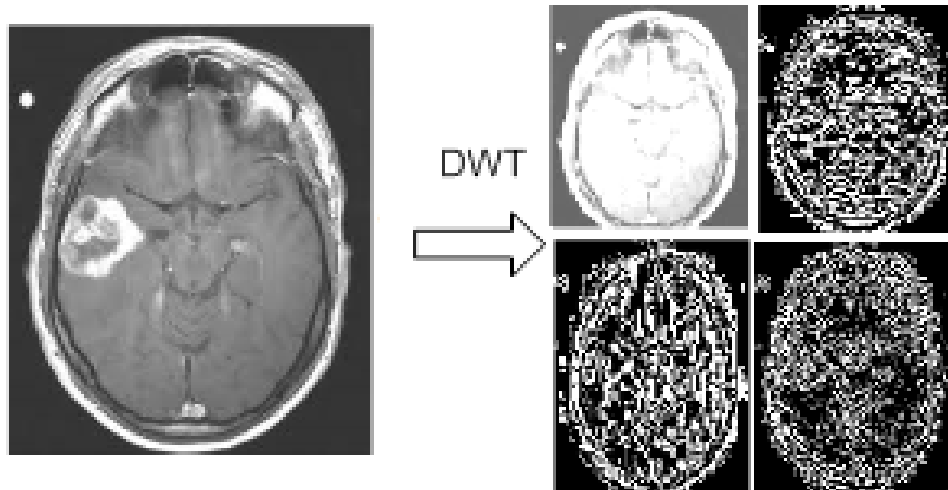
MRI image and first level of DWT.
